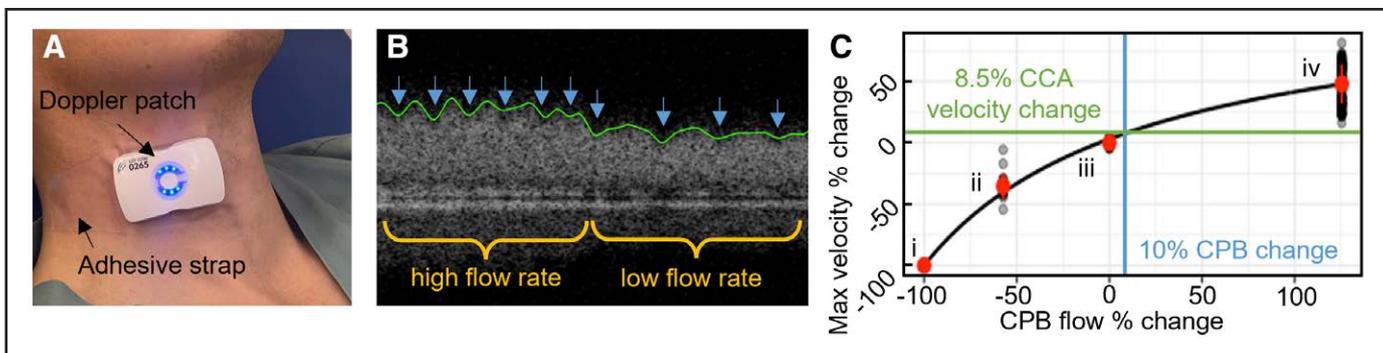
Using the Doppler patch to compare changes in common carotid artery (CCA) velocity to changes in cardiopulmonary bypass (CPB) pump flow rate. A, CW Doppler patch in place over CCA. B, Displayed spectrogram during a change in flow rate, showing maximum CCA velocity trace (green line) and CPB pump pulsations (blue arrows). C, Dose-response curve (black line) fitted to changes in CPB pump flow and corresponding changes in CCA maximum velocity for a single subject. (i) Inferred point representing zero flow, (ii) negative CPB pump flow change, (iii) baseline CPB pump flow and baseline CCA maximum velocity, (iv) positive CPB pump flow change. The red points indicate the overall mean CCA velocity change for each of the time windows, while the black points show the variability of each 0.5 s segment of the corresponding windows. The change in CCA velocity corresponding to a 10% change in CPB pump flow was determined from the equation of the dose-response curve to be 8.5% with a 95% CI of (5.0–12.0%).
